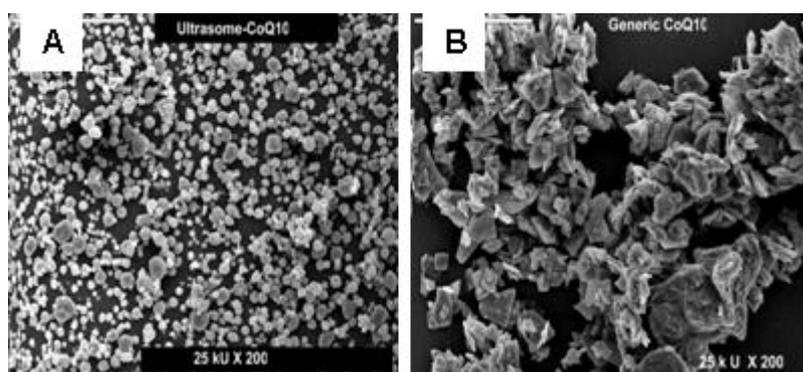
Particle size of Ultrasome™-CoQ10 (A) compared to generic CoQ10 (B). The particle size is one of the factors that affect the dissolution rate. Ultrasome™-CoQ10 represented by small, homogenous and uniform particles compared to large and heterogeneous particles of generic CoQ10.
